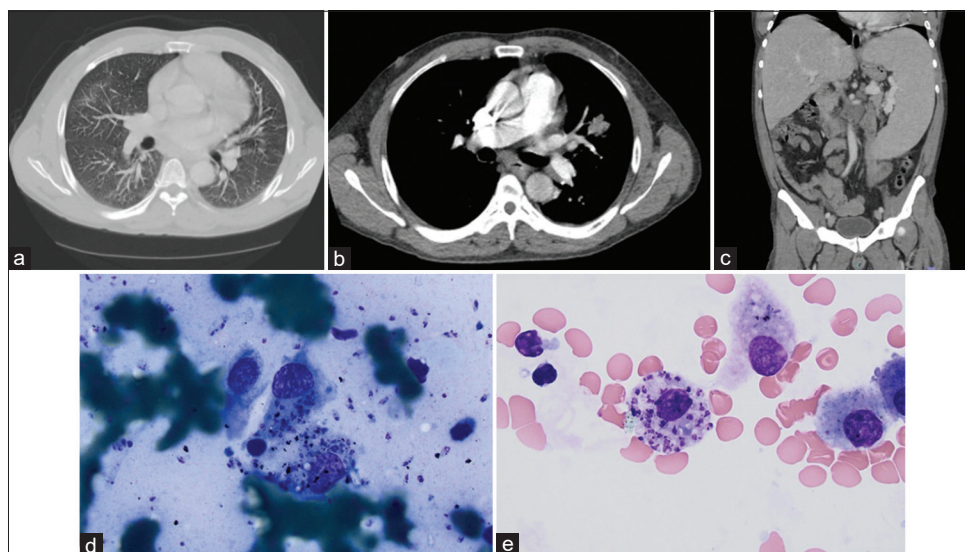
(a) Chest CT scans (lung window) in axial view showing ground glass opacities. (b) Chest CT scans (mediastinal window) showing mediastinal adenopathy. (c) CT scans in the coronal window showing hepatosplenomegaly, particularly massive splenomegaly. (d) Smears of EBUS-TBNA showing numerous intra and extra-cellular oval bodies within macrophages consistent with leishmania amastigotes. (e) BAL smears showing the leishmania amastigotes
